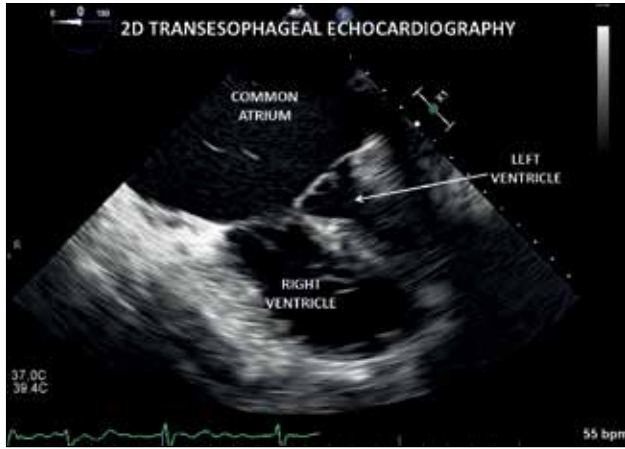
Two-Dimensional transesophageal echocardiography image displaying common atrium, small left ventricle and relatively larger right ventricle
